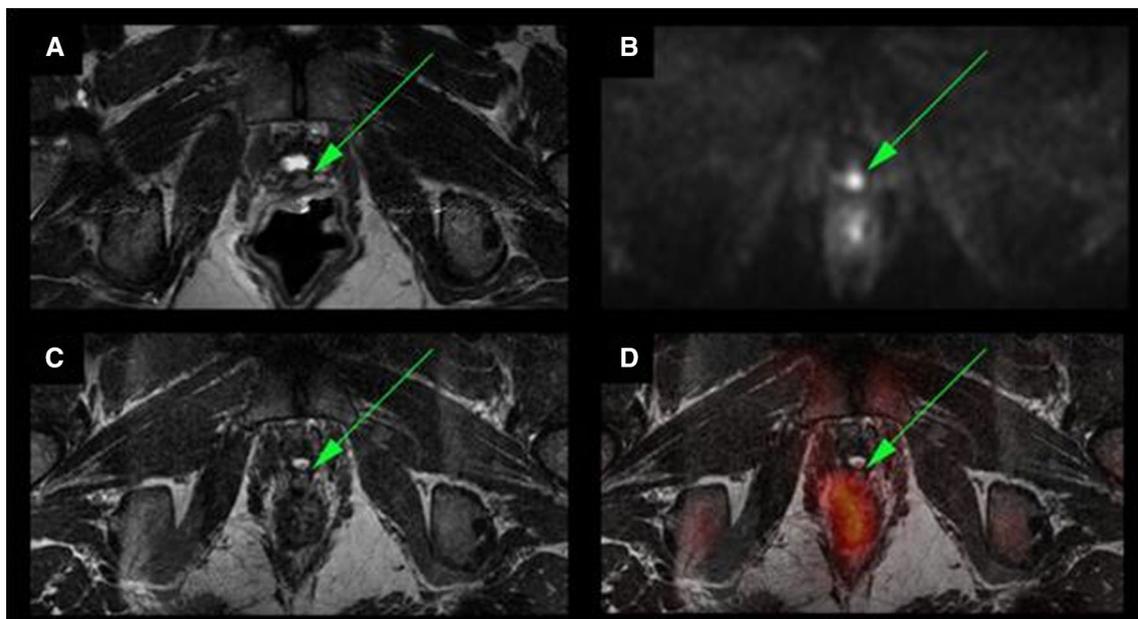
mpMRI images showing a local recurrence with negative FCH findings in a 55-year-old man with a pT3 pN0 R1 Gleason 3+4 disease in biochemical recurrence (PSA 0.56 ng/ml) after radical prostatectomy. a T2-weighted images, b diffusion-weighted images, c
